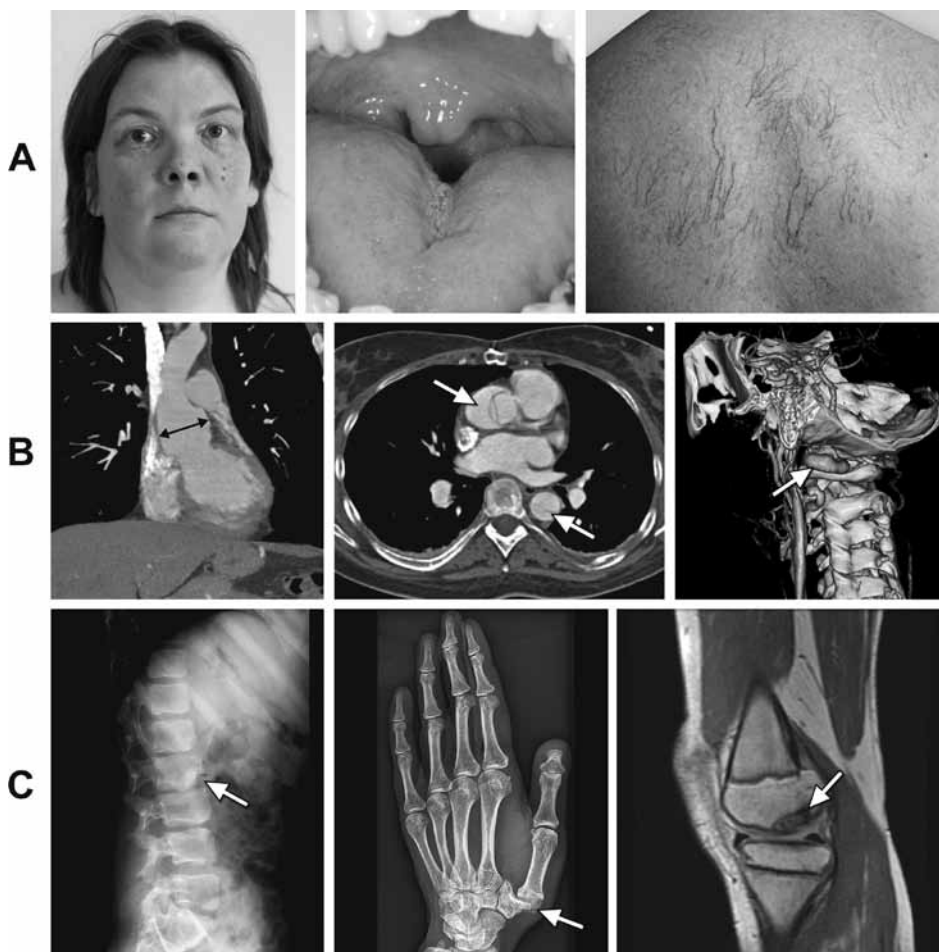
Clinical features of cases from family 1. Written consent was obtained for publication of these images. (a) Physical examination (from left to right). Facial features including a long face, hypertelorism, flat orbital ridges and malar flattening in individual IV-10; bifid uvula in individual IV-9; and translucency of the skin with visible thread veins in individual III-6. (b) Aneurysms and dissections (from left to right). Multi-slice computed tomography angiogram of thoracic aorta showing an aneurysm of the aortic root (45 mm, arrow) of individual IV-11 at the age of 29 years; multi-slice computed tomography angiogram in 50-year-old female (individual III-12) shows a Stanford type A aortic dissection (arrows) with dissection flap extending from the aortic valve into the descending aorta at a maximal aortic diameter of 40 mm; and a 3D-reconstructed computed tomography angiogram (left posterior view) shows a fusiform aneurysm of the left vertebral artery (arrow) in a 46-year old female (individual IV-1). (c) Osteoarthritis and osteochondritis (from left to right). A 12-year-old boy (individual V-3) with early degenerative abnormalities of the lumbar spine, deformations of the vertebral body (arrow) and narrowing of the intervertebral disc space at multiple levels; advanced osteoarthritis of the first carpometacarpal joint of the left hand (arrow) in a 46-year old female (individual IV-1); and magnetic resonance imaging of the left knee of 12-year-old individual (individual V-3) shows a large osteochondral lesion without separation in the medial femoral condyle (arrow).
